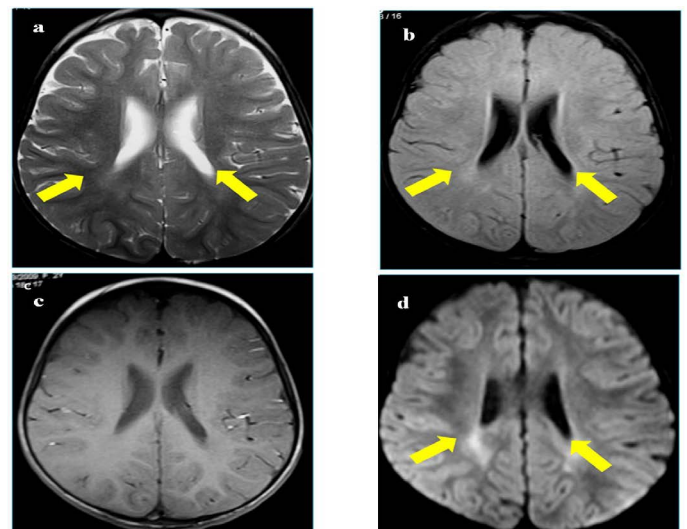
a. Cerebrospinal MRI showing an hypersignal T2; b. FLAIR; c. prominent periventricular white matter posteriorly and appearing in isosignal T1; d. with restriction of ADC on the weighted diffusion sequence as b1000
